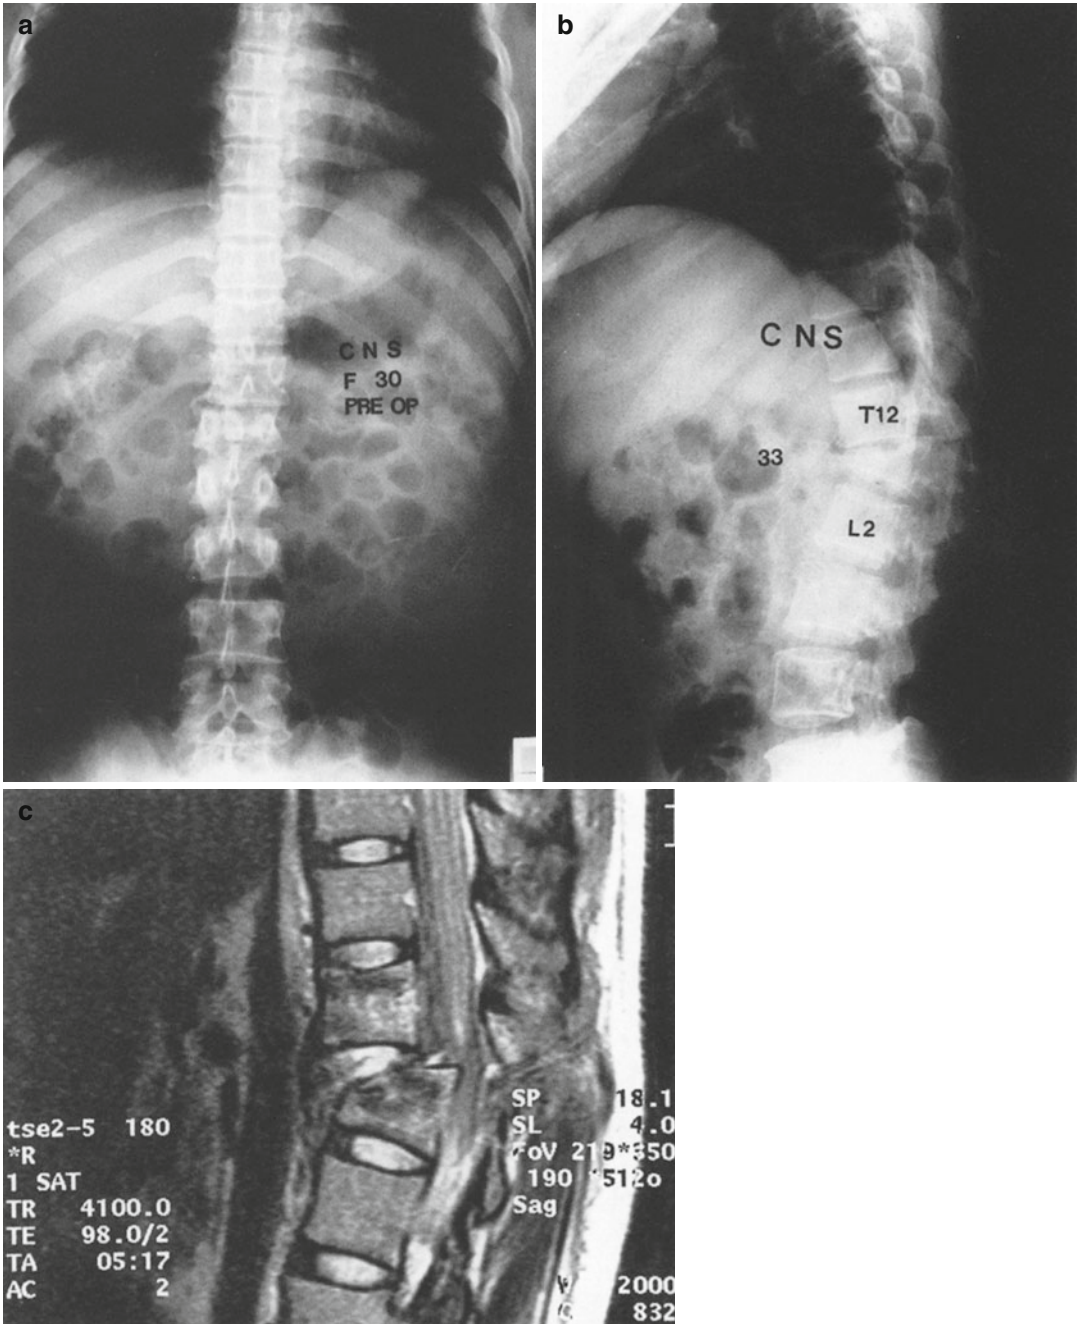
(a, b) A 30-year-old female with T12 L1 fracture dislocation. C MRI shows gross displacement. (d, e) She was treated by posterior instrumentation in neutral mode and then anterior column reconstruction
